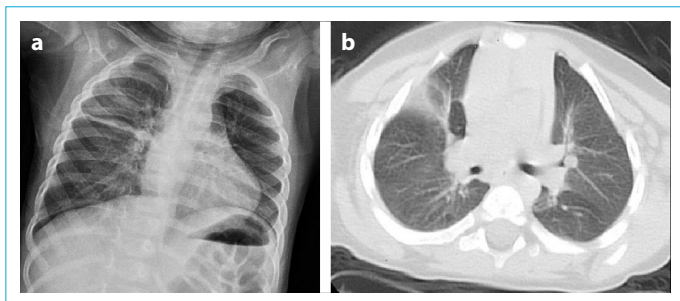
(a, b) 2 years old boy admitted to the emergency room with fever. In chest X-ray before performing CT, linear atelectasis was seen at the middle zone of right lung.
